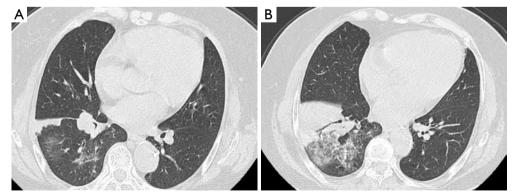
A 75-year-old female using clinical manifestation and radiographic imaging was finally diagnosed lung cancer although OP was given by CT-guided lung biopsy. (A) Soft tissue mass located in the bronchus of the right lower lung, indicating potential lung cancer; (B) consolidation and ground glass opacities apparent in the right lower lung. Air bronchogram signs were also apparent in the consolidation. lung biopsy on this region revealed OP pathologically. OP, organizing pneumonia.
